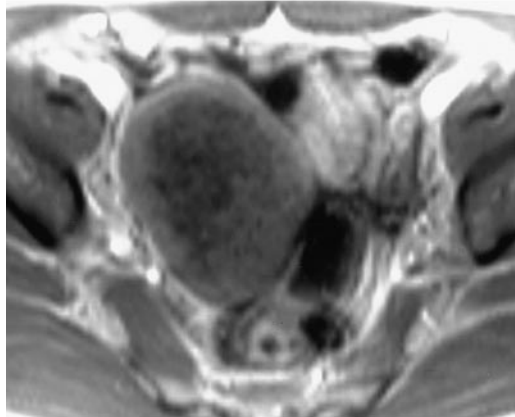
Fibroma in a 53-year-old woman. (a) Conventional radiograph shows dense amorphous calcification in the pelvic cavity. The initial diagnosis was leiomyoma with dystrophic calcification. (b) Axial turbo spin-echo T1-weighted MR image (800/12) shows a well-defined round mass (*M*) with extensive low-signal-intensity foci representing calcifications. *U* = uterus. (c) On an axial turbo spin-echo T2-weighted MR image (5,200/132), the mass (arrows) has low signal intensity with high-signal-intensity foci. A small amount of ascites is present in the cul-de-sac (*).
